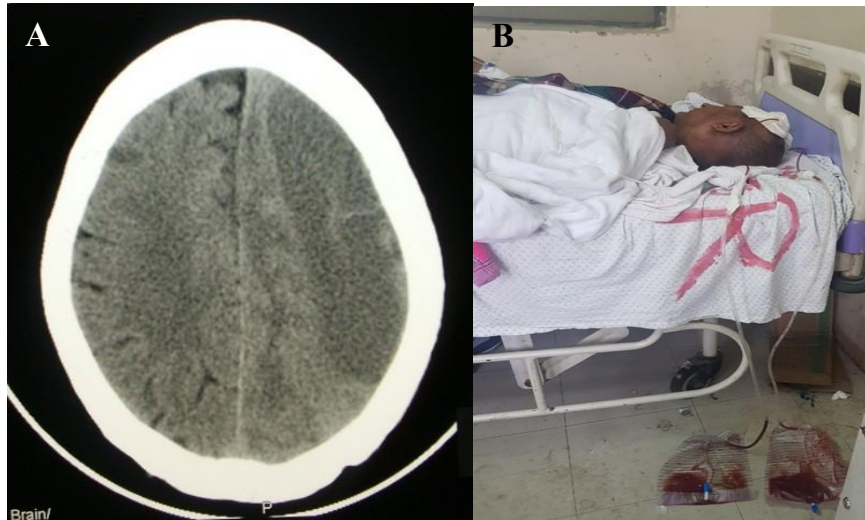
Management of chronic subdural hematoma. (A) Non-contrast enhanced CT scan showing a left-sided chronic subdural hematoma. (B) Postoperative drainage after surgical treatment. Photos: Tsegazeab Laeke.
